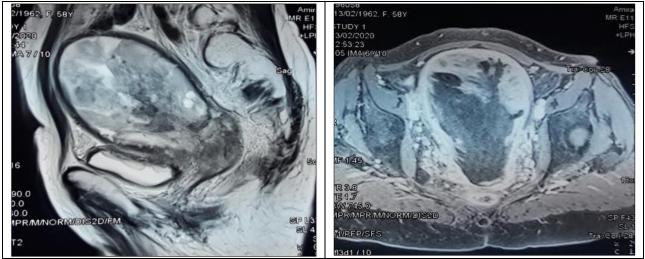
Sagittal T2 and axial T1 sections of a pelvic MRI showing irregular endometrial thickening with significant fluid retention in our patient
